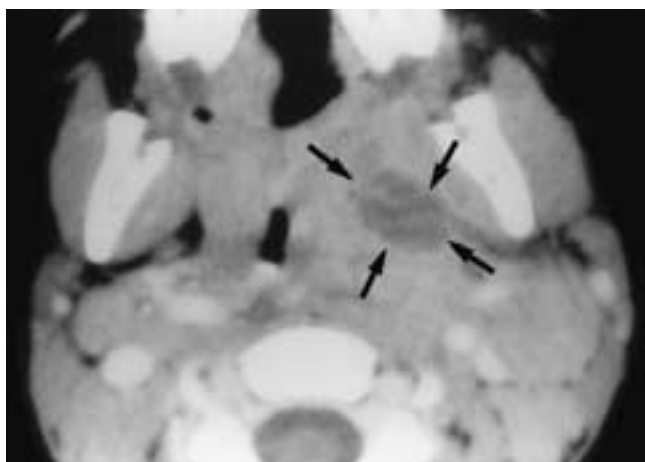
Axial contrast-enhanced CT scan shows a left peritonsillar abscess extending into the left parapharyngeal space (*arrows*). Note that it is located lateral to the left tonsil. Based on its location, it was drained by a cervical approach rather than by intraoral drainage, as would normally be performed for a tonsillar abscess.
